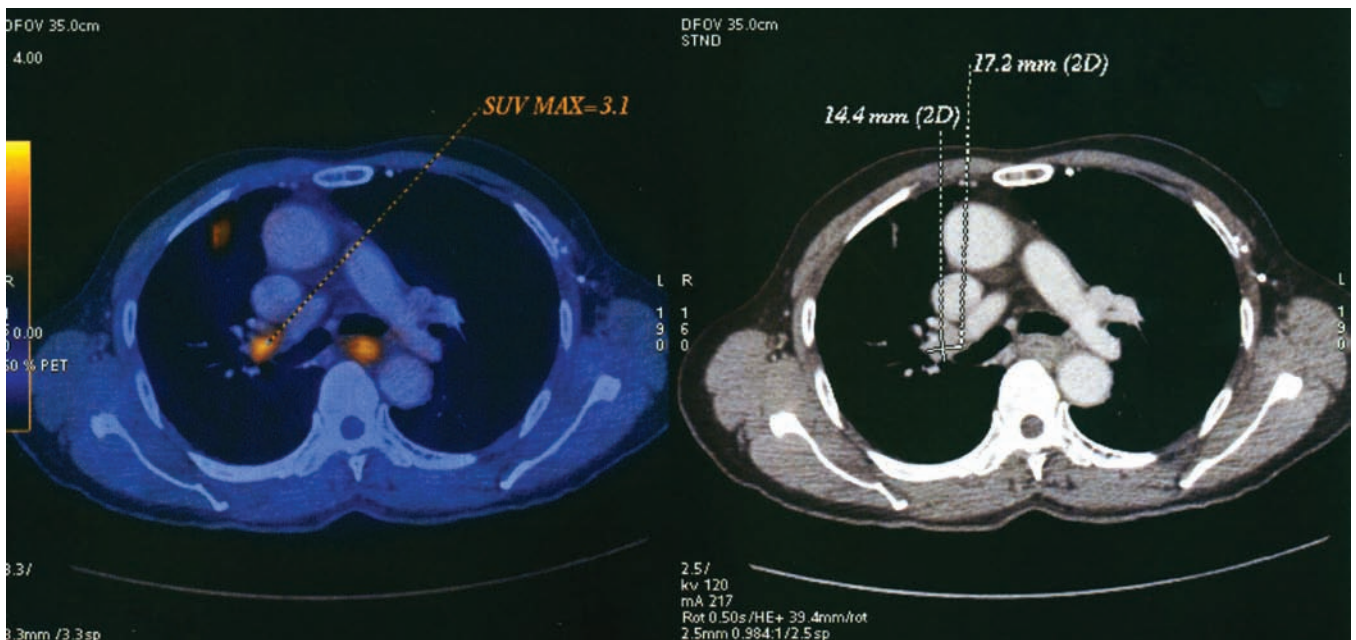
Combined PET and CT image: in addition to size of lymph nodes, the standard uptake value often will help to determine if the lymph node is involved by cancer. A right pulmonary hilar node identified with its corresponding PET image. Standard uptake value (SUV) uptake was 3.1.
